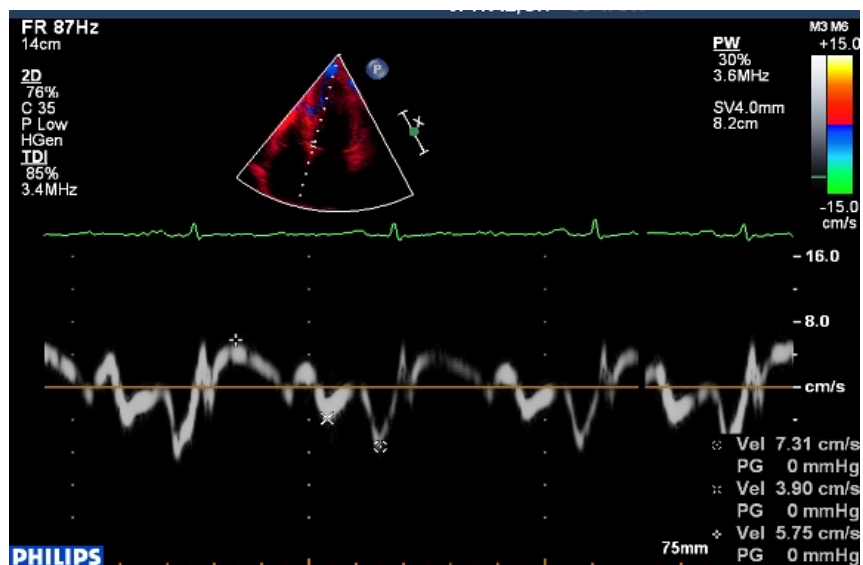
Tissue doppler across medial mitral annulus showing reduced Ea value of 3.9cm/s and E/Ea value of this patient was 23.4, which is markedly abnormal.
